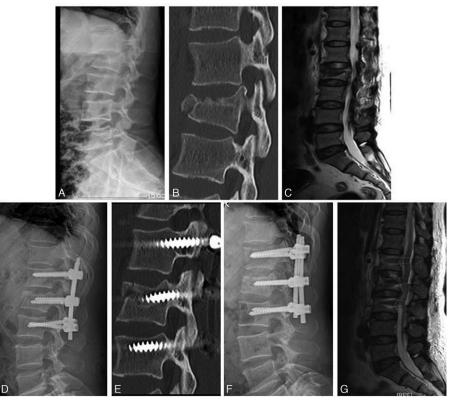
A 48-year-old woman who had a burst fracture at L2 vertebra. Preoperative lateral radiograph (A) and CT (B) showed a fracture fragment at the anterior column of L2 vertebra. Preoperative MRI (C) showed Pfirrmann grade 1 of L1-L2 disc and Pfirrmann grade 2 of L2-L3 disc. X radiograph and CT immediately after surgery (D, E) revealed the fracture fragment at the anterior column was reduced. After follow-up for 12 months, X radiograph (F) showed healing of T12 fracture and MRI (G) showed no progress to degeneration. CT = computerized tomography, MRI = magnetic resonance imaging.
